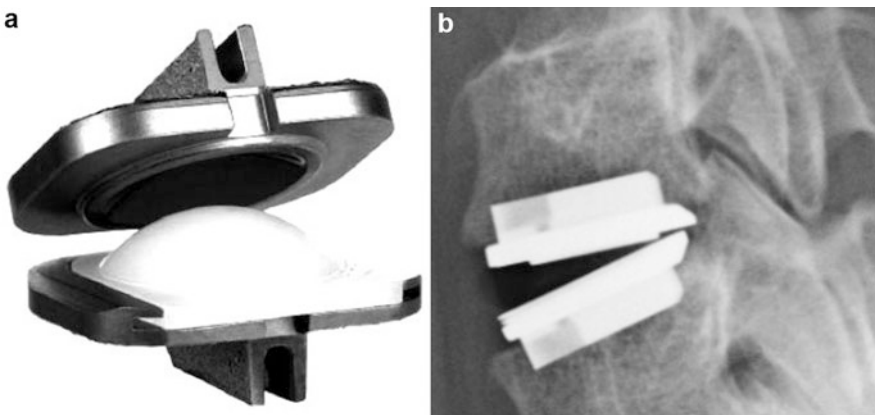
ProDisc-C cervical disc: (a) device; (b) lateral X-ray after implantation
